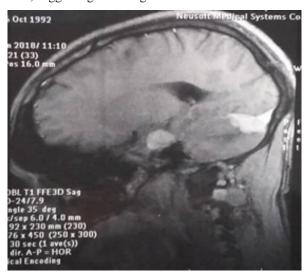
Brain MRI, axial section, T1-weighted sequence with gadolium, evidence of hypersignals at the hippocampal and cerebellar level resting on meninges suggestive of meningiomatosis.
